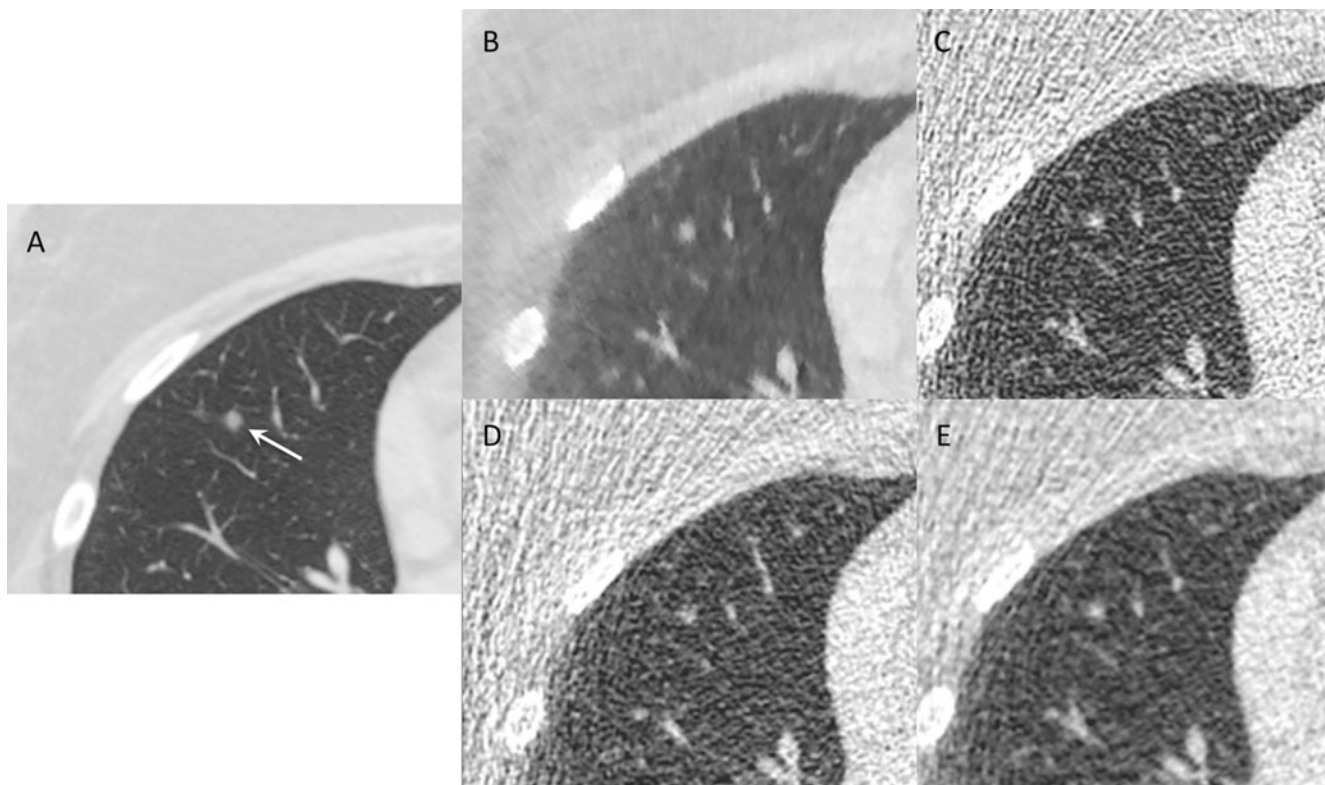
Nodules. Diagnostic CT showing a 5-mm nodule (arrow) in the right middle lobe (a). The same nodule seen on ULD-CT, reconstructed with MBIR (b), FBP (c), ASIR-40 (d) and ASIR-80 (e) algorithms
